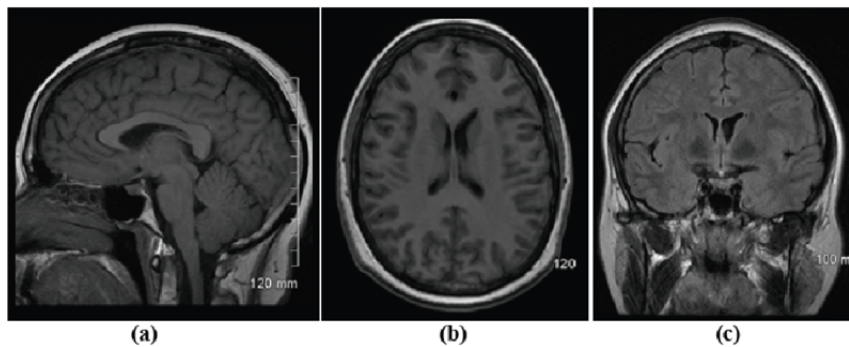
MRI planes for MRI head scan (a) sagittal, (b) axial and (c) coronal [91]
